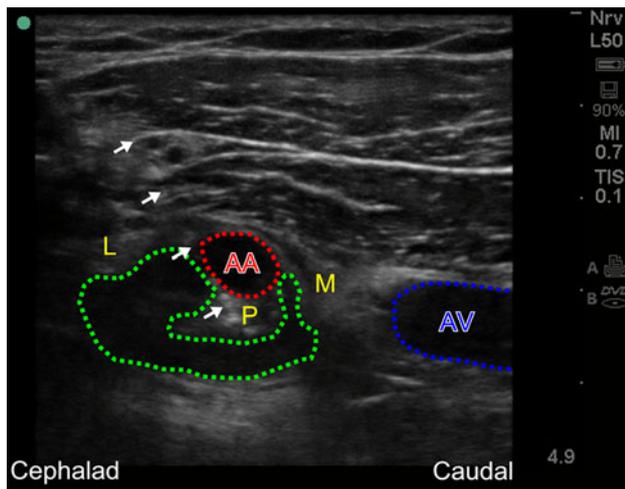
Figure Ultrasound image showing the outlines of the axillary artery (AA) and vein (AV) and the positions of the lateral (L), posterior (P), and medial (M) cords of the brachial plexus. Needle position (arrows) and local anesthetic spread (green dashed line) are indicated
